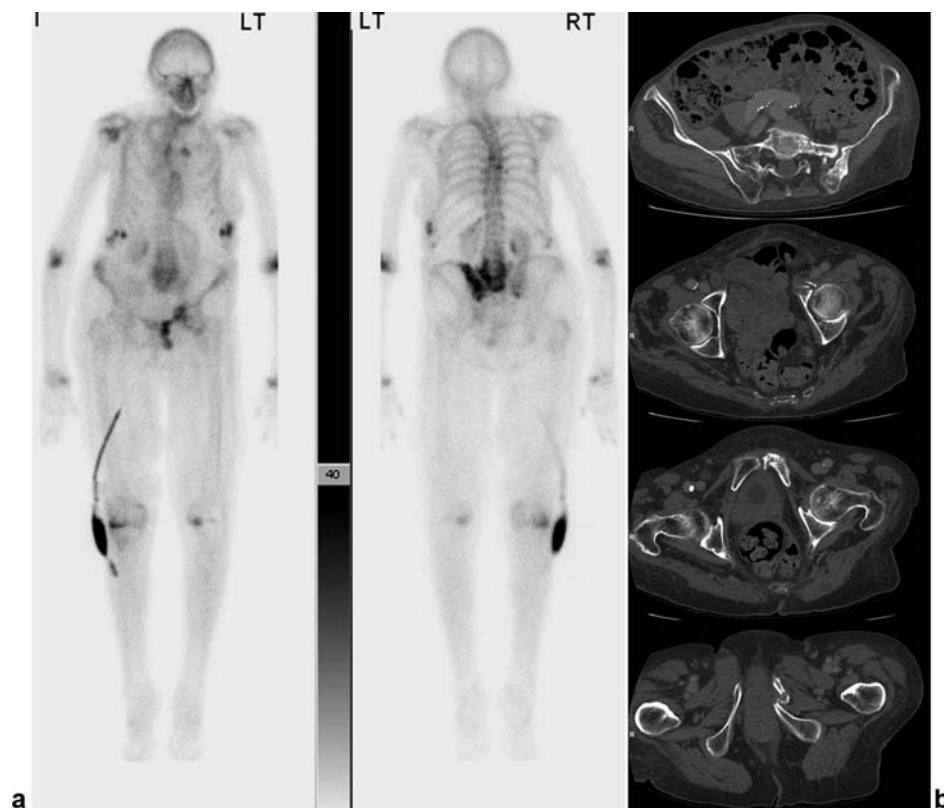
(a) Whole-body bone scintigraphy in an elderly woman showing increased activity over the left sacrum, ilium, acetabulum, pubis, and inferior pubic ramus suspected to be metastases. (b) Transverse computed tomography revealed insufficiency fractures at all five sites.
